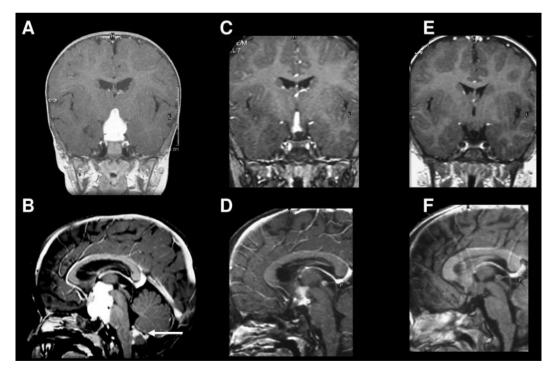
Case 2. Pre-operative gadolinium-enhanced coronal (A) and sagittal (B) brain MR images showing a chiasmatic-hypothalamic solid mass with homogeneous enhancement and CSF disseminations around the cerebellum (arrow). Gadolinium-enhanced brain MR images (C and D) show tumor size remarkably reduced after five courses of a second chemotherapeutic treatment (cisplatin, etoposide, vincristine, cyclophosphamide). After eleven courses, the patient achieved complete remission (E and F).
